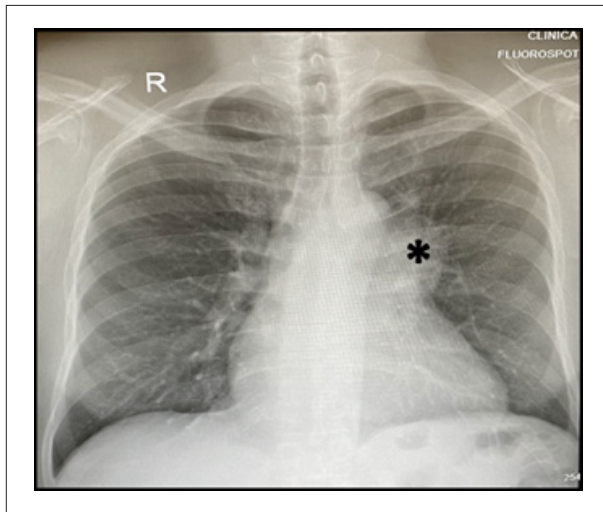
Chest X-ray showing enlargement of the left hilum (asterisk), parietal thickening to the left, enlarged cardiac silhouette to the left at the expense of the left ventricle
